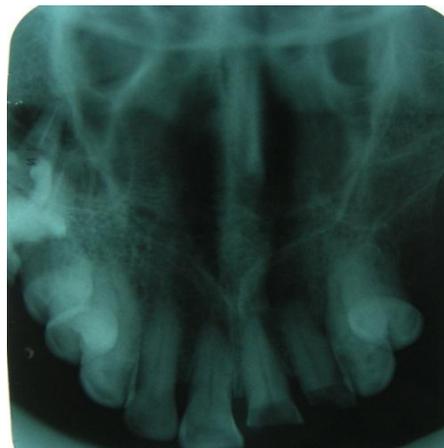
Occlusal radiograph of maxilla showed an irregular and ill defined radiolucent area in the mid-hard palatal region present
